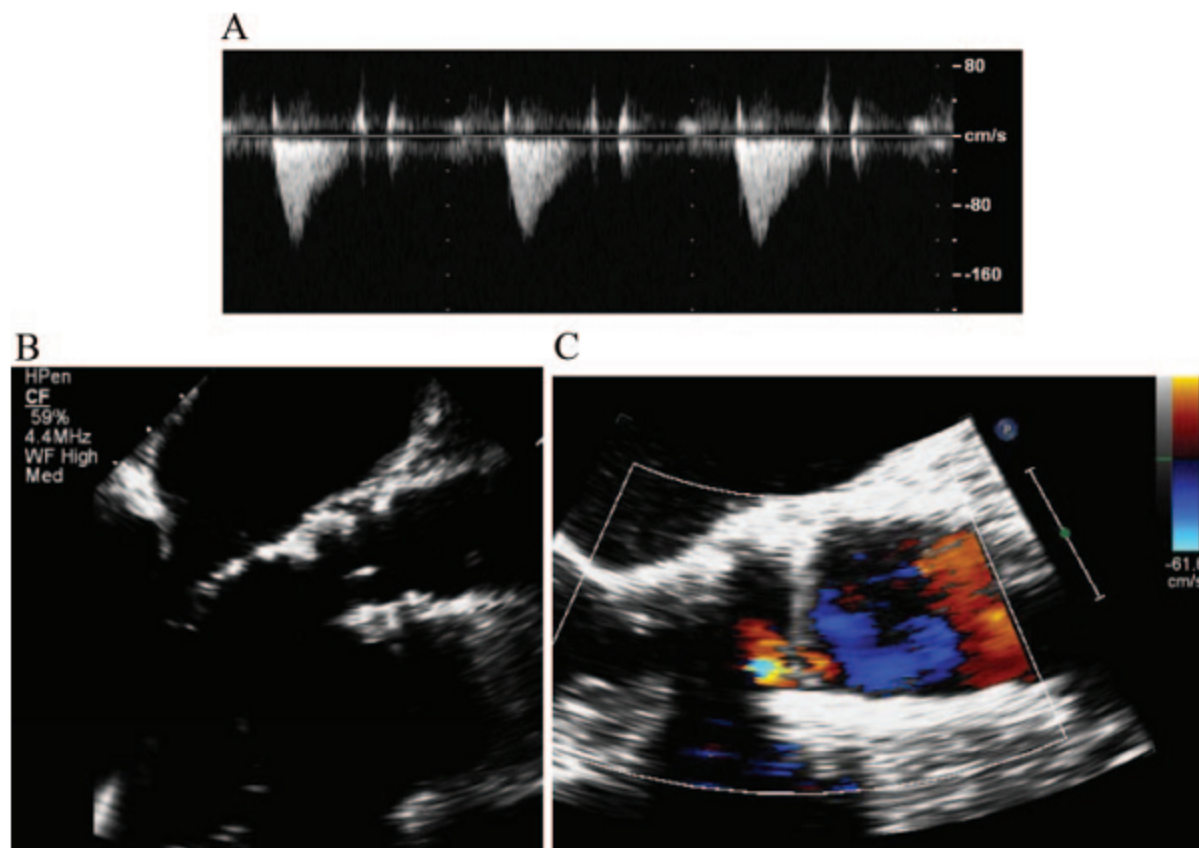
Transoesophageal echocardiography images immediately after implantation of the Sapien valve. A, Low aortic transvalvular gradient; B, thin and normal leaflets; C, trivial aortic regurgitation.
